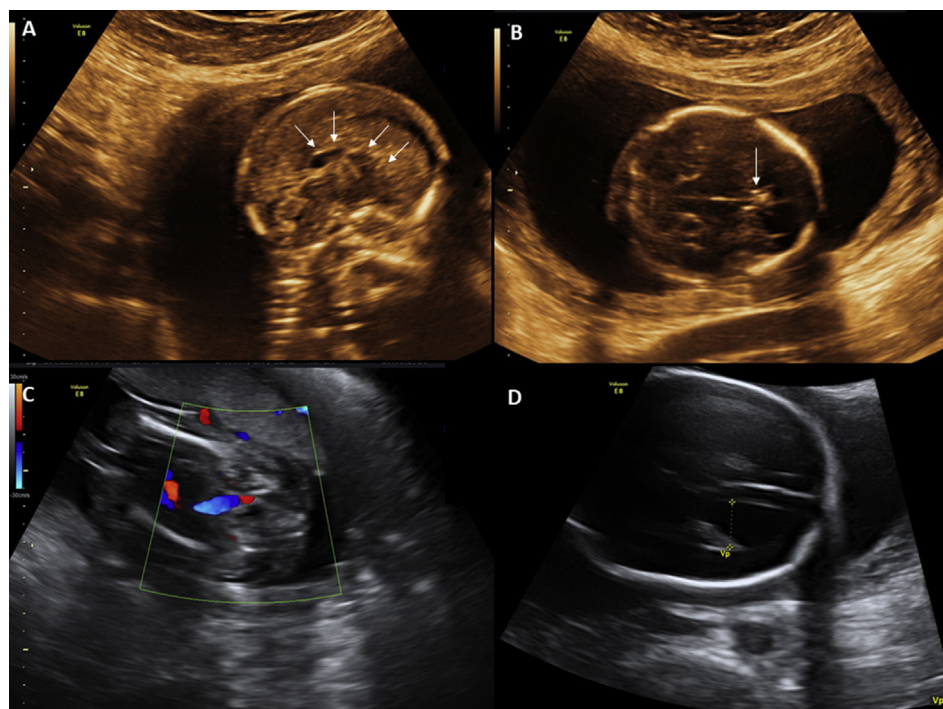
Ultrasound imaging (2D) revealing complete agenesis of corpus callosum indicated by white arrows (A) and absent cavum septi pellucidum indicated by white arrow (B). Single umbilical artery (C). Mild ventriculomegaly (D).
